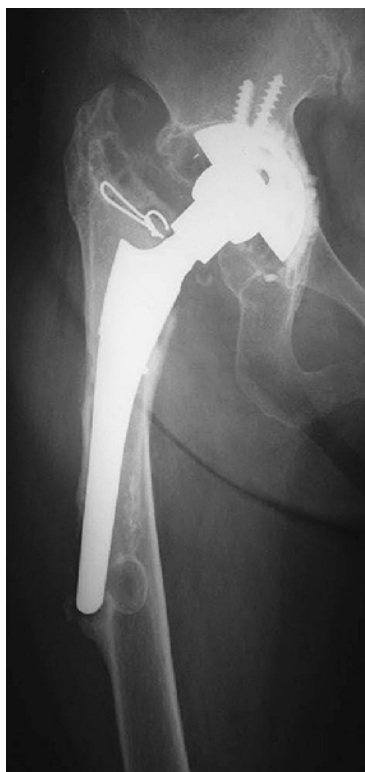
Radiograph taken at pre-revision total hip arthroplasty of the right side.
